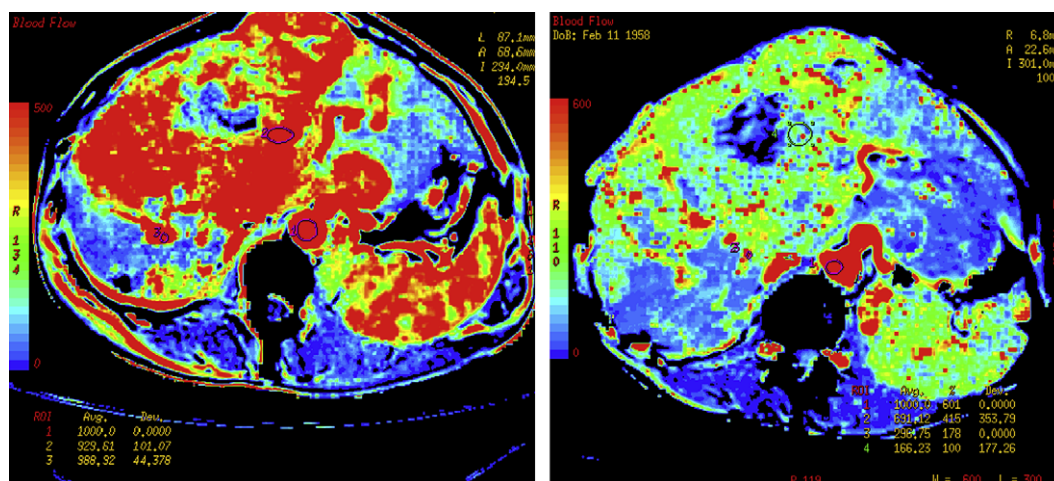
Pre- and post-anti-angiogenic therapy CT perfusion maps (study courtesy of D. Buthiau, O. Rixe, J. Bloch, J.B. Méric, J.P. Spano, D. Nizri, M. Gatineau, D. Khayat).
